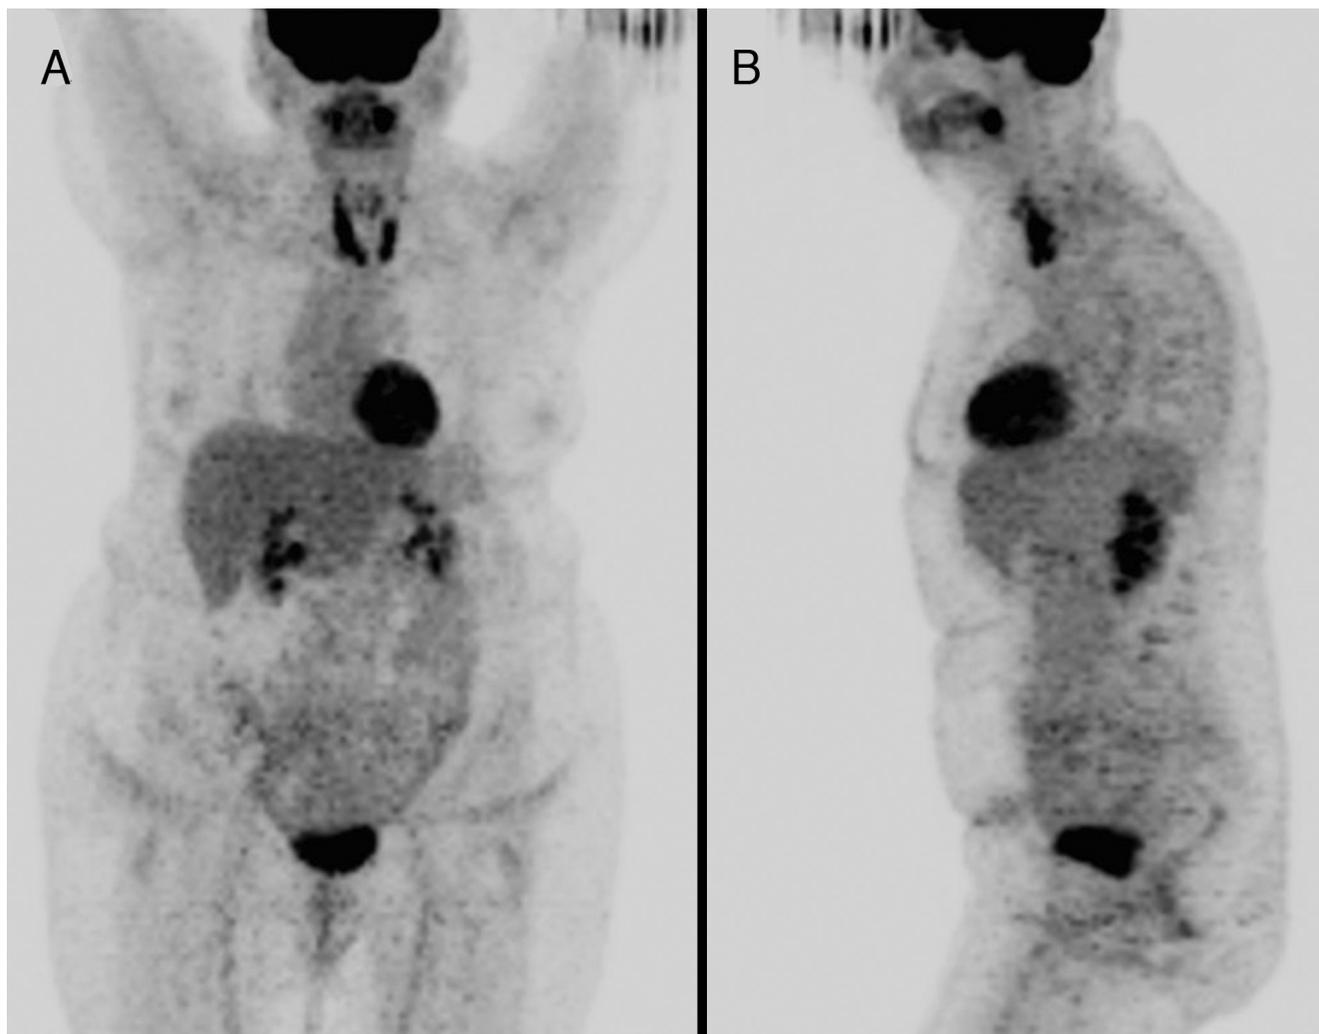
A second follow-up PET/CT was performed one year later. SUV_{max} of right thyroid lobe was 10.2, unchanged according to PET Response Criteria in Solid Tumors (PERCIST 1.0). The pattern of ^{18}F -FDG uptake and distribution in the thyroid gland were also unchanged. Biopsy of both thyroid lobes revealed thyroiditis with no evidence of residual lymphoma. A third follow-up PET/CT was performed 2 years later and SUV_{max} in the right thyroid lobe was 9.5 (unchanged according to PERCIST) with stable pattern of ^{18}F -FDG uptake and distribution, consistent with remission. Primary thyroid lymphoma makes up 1-5% of thyroid malignancies and less than 2% of extranodal lymphomas (1). It is more common in women, and patients present in the seventh decade of life with rapidly enlarging neck mass (1,2,3,4). The use of ^{18}F -FDG PET/CT to stage primary thyroid lymphoma and evaluate response to therapy has been previously reported in the literature (5,6). Recent studies have raised concern about high rate of false positives on PET/CT performed following therapy for thyroid lymphoma, although these have been attributed to Hashimoto's thyroiditis (7,8,9,10,11,12). External beam radiation therapy can produce both inflammatory and proliferative changes in the thyroid gland with increases in macrophage populations (9,10). Studies have shown that ^{18}F -FDG uptake is increased in head and neck soft tissues affected by such inflammatory and proliferative processes and lasts several months after the completion of radiation therapy (11,12). The present case is an example of a long-term post-treatment thyroiditis, which remained intensely ^{18}F -FDG avid but stable on several follow-up PET/CTs spanning three years, which to our knowledge has not been previously reported in the literature.
